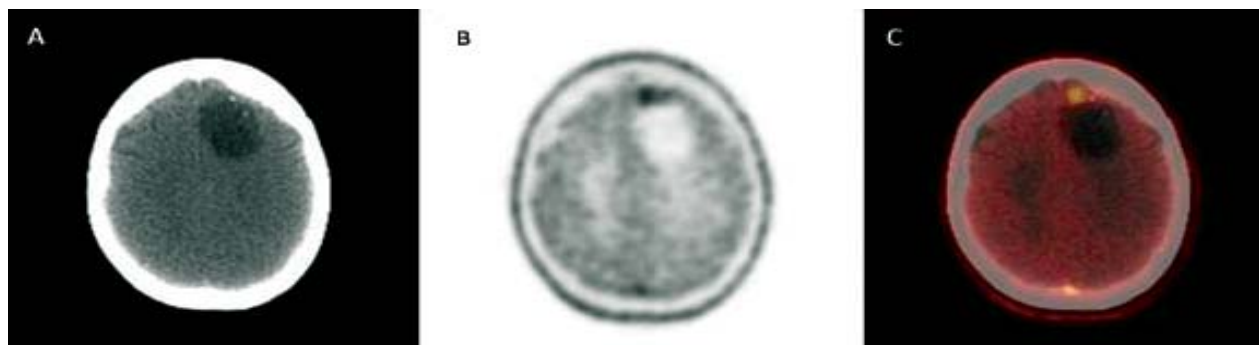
34-year old patient suffering from recurrent astrocytoma grade III and condition after multiple resections referred for [ $^{18}\text{F}$ ]FET PET/CT for re-staging. PET/CT revealed focal uptake left frontal indicating local recurrence. (A) CT, (B) PET, (C) PET/CT fused images
